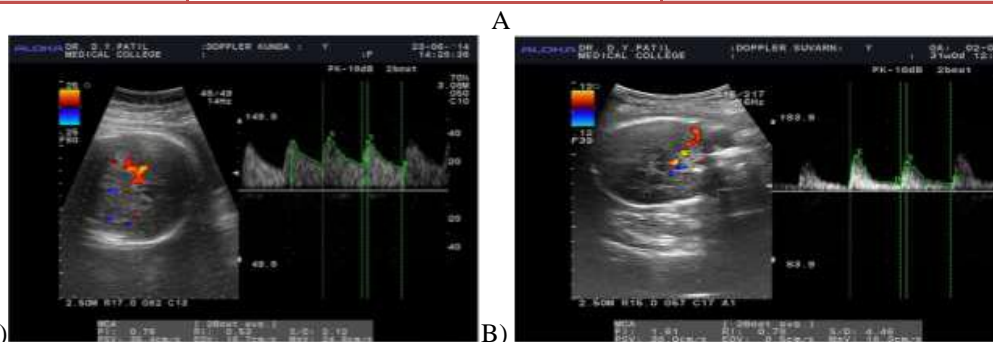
A) Showing reduced Doppler indices reflecting “Brain sparing effect” in the MCA. B) Showing a pseudo-normalization of Doppler indices in the MCA due to underlying cerebral oedema (Reversal of Umb a diastolic flow was noted in the same patient).
